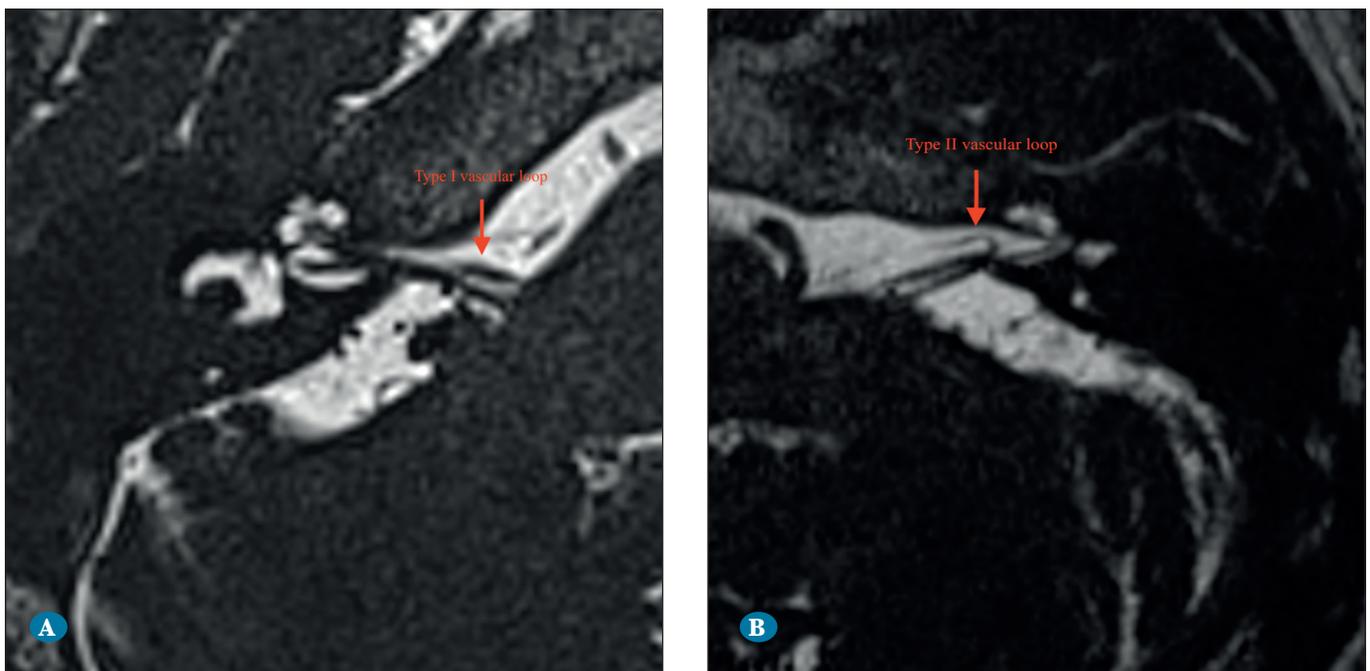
Axial thin-section 3D T2W MRI, (A) a type 1 vascular loop on the right side, and (B) a type 2 vascular loop on the left side. (MRI: magnetic resonance imaging, 3D: 3-dimensional, T2W: T2-weighted).
